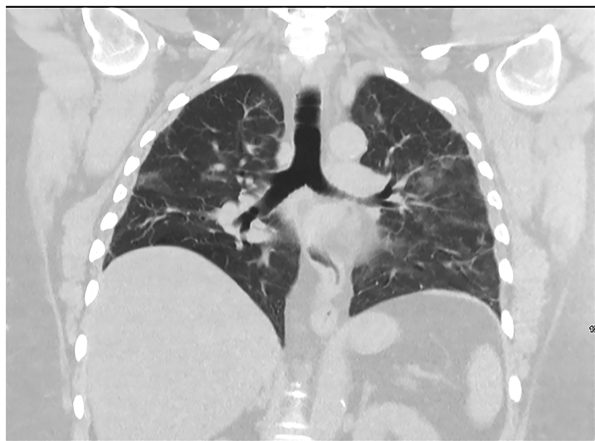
Coronal CT Thorax imaging demonstrates lung scarring.
